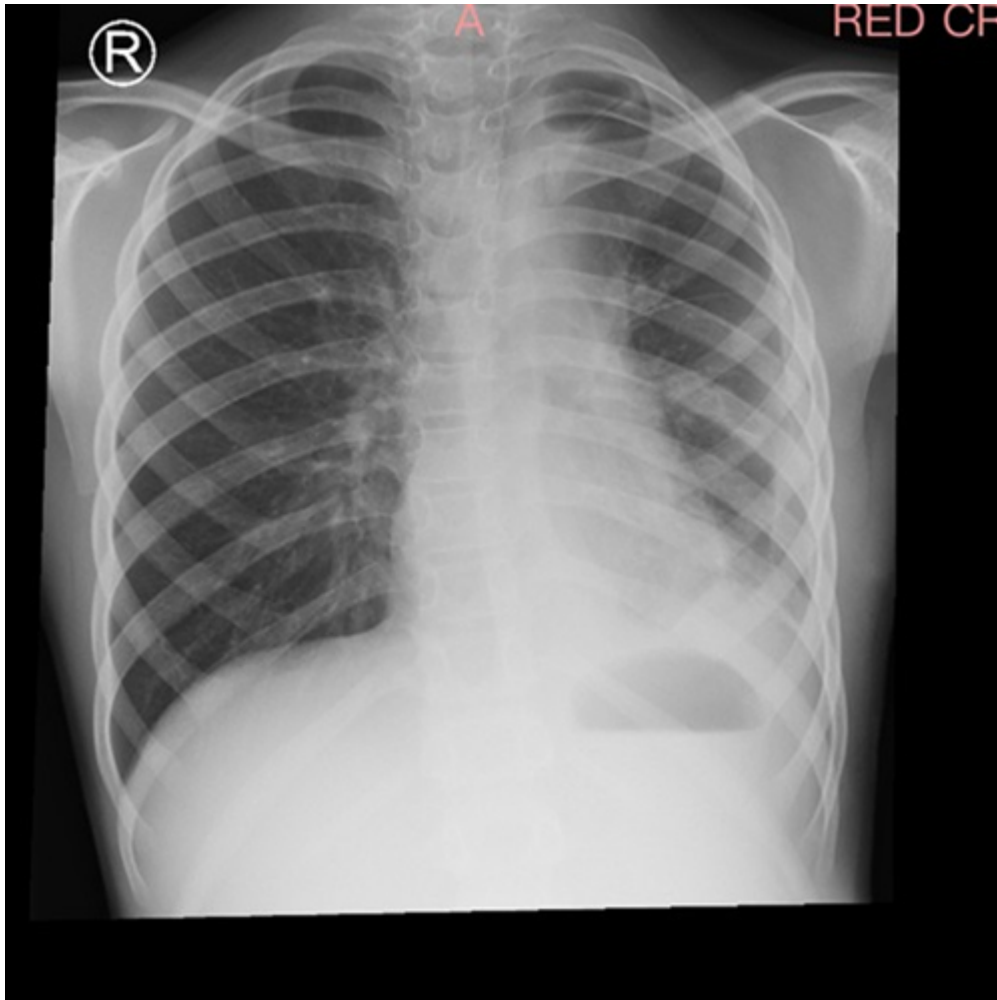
Postoperative chest radiograph showing marked re-expansion of the left lung.
